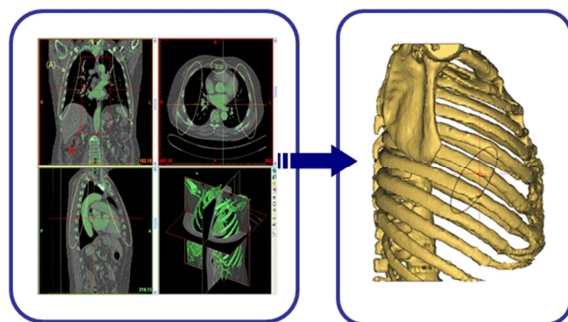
3D Reconstruction of rib fractures using CT images
